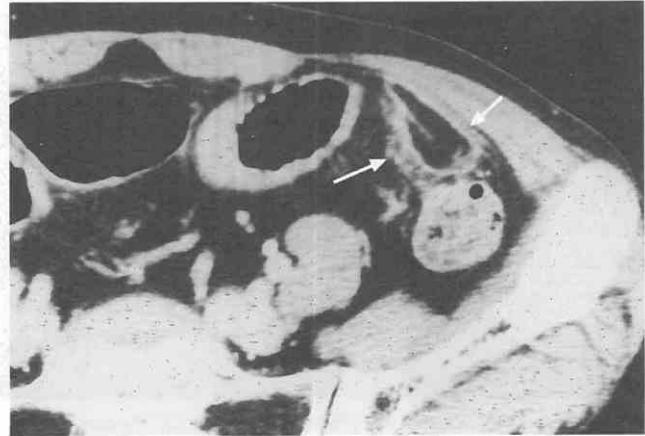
Appendagitis in patient with left lower abdominal pain and tenderness, mild fever, and leukocytosis. CT scan shows a pericolic, oval-shaped, fatty lesion (arrows) with an enhancing peripheral wall. Pericolic fat strands also surround this lesion.
